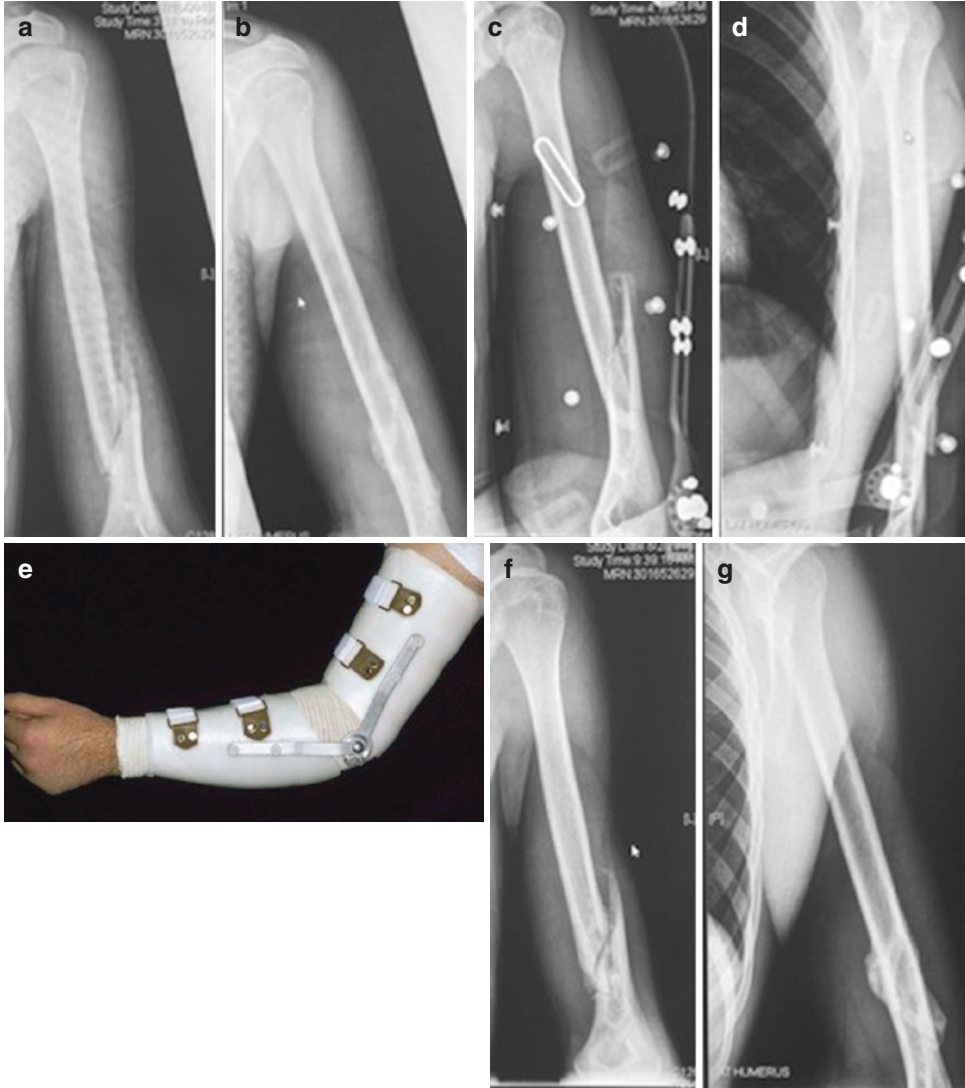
Lateral (a) and oblique (b) radiographs of a closed, displaced spiral fracture of the left humerus in a young healthy male involved in a motor vehicle accident. Oblique (c) and lateral (d) radiographs of the spiral humerus fracture depicted in a and b, 10 days post-injury, the patient has now been placed in a prefabricated fracture brace, with an elbow hinge (e). Anteroposterior (AP) (f) and lateral (g) radiographs, 2 months post-injury. The
